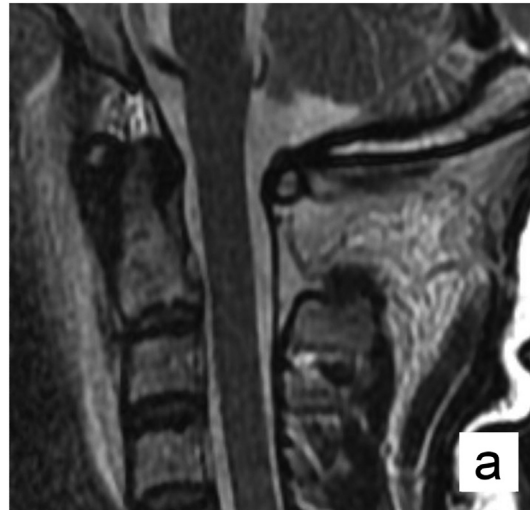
Preoperative MRI T2 sequence mid-sagittal slice reveals no damage to intervertebral disc between C1 and C2 vertebrae.
